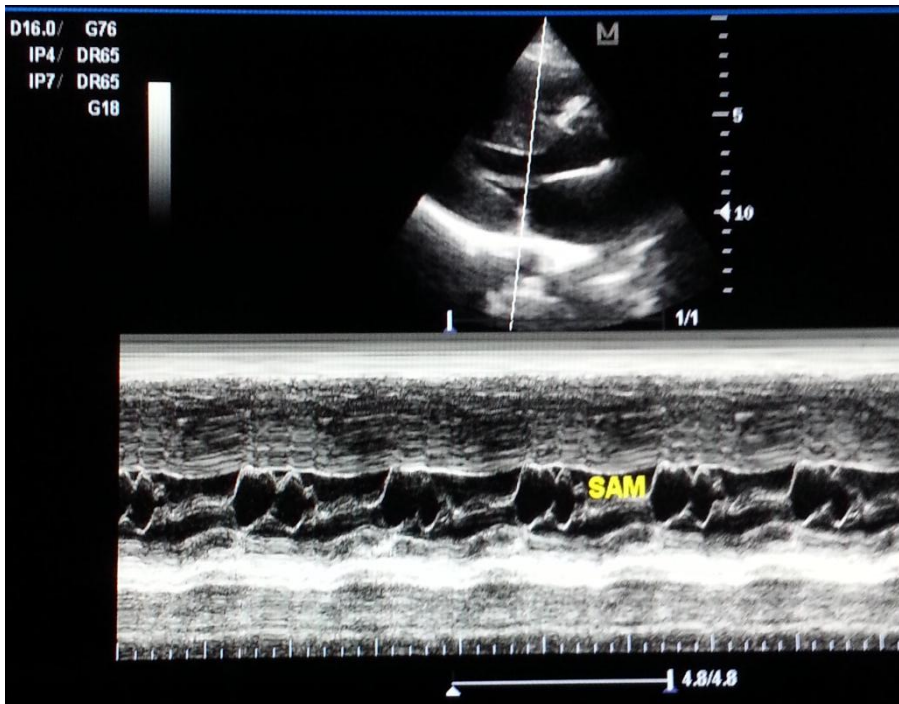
2D guided M mode echocardiogram showing systolic anterior motion (SAM) of the mitral valve leaflet.
